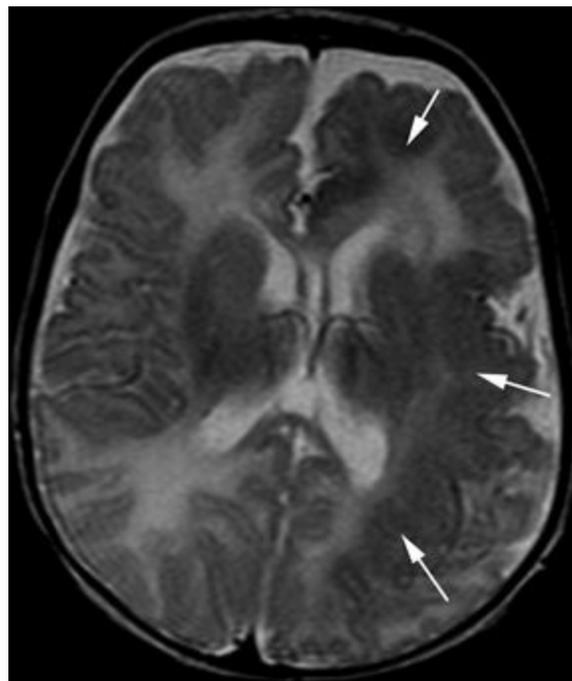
Hemispheric malformation of cortical development. Axial T2-weighted image from MRI without gadolinium in a 4-year-old boy with intractable infantile spasms since birth shows diffuse left hemispheric cortical thickening with lack of normal arborization of white matter (arrows).
